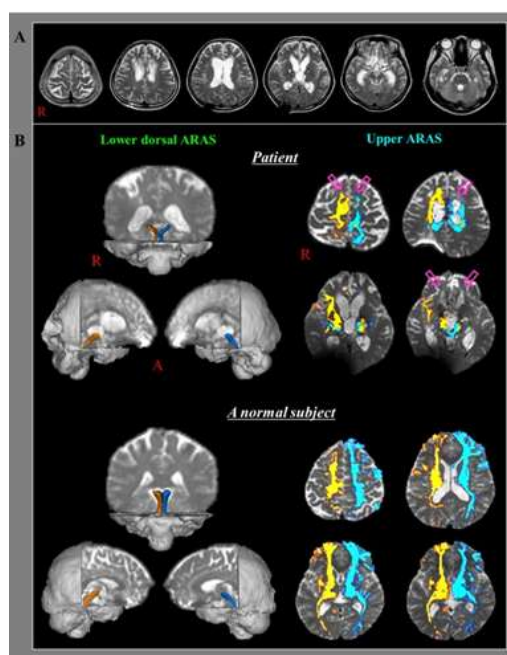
(A) Brain MR images at four and ten months after onset show leukomalactic lesions in the right basal ganglia, thalamus, and both brainstems.(B) Results of diffusion tensor tractography for the ascending reticular
